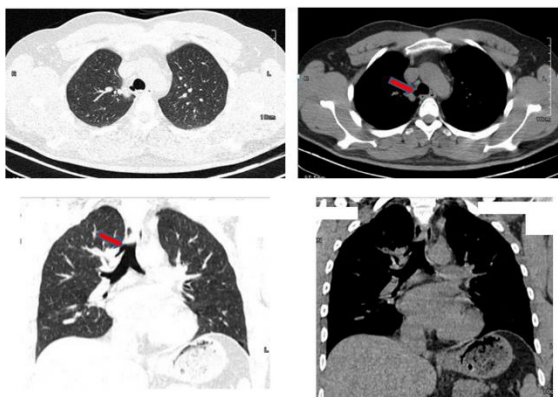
Axial and coronal non-contrast-enhanced image of computed tomography (CT) scan of the chest. The RT tracheal bronchus (red arrow)
